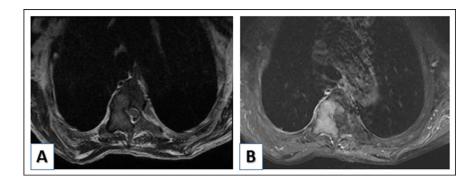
Spinal magnetic resonance imaging shows osteolytic lesions in the dorsal spine in intermediate signal in T2, enhanced after injection, complicated by spinal cord compression.
